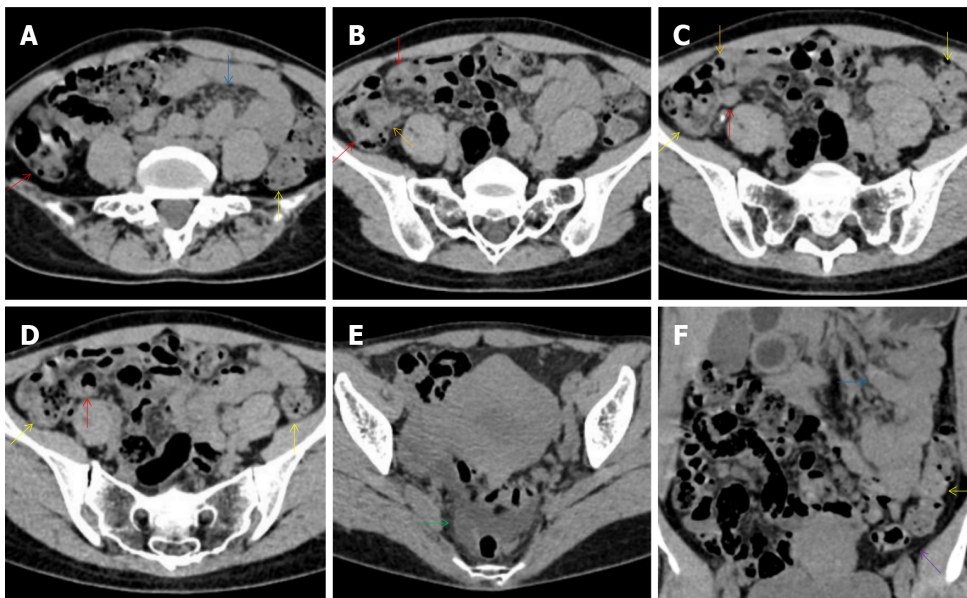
Characteristic images in case 8. A-C: Characteristic images of the ileocecal region and the small intestine. The ileocecal valve (red arrows) was thickened, strictured and stratified. The distal ileum (yellow arrows) were significantly thickened with intramural gas and wrapped by prominent mesenteric fat stranding, which suggested the presence of aggravated inflammatory damage in the distal ileum and ileocecal region; D-H: Characteristic images of the small intestine. In the ileocecal region, the ileum adhered to the cecum, and the cecum was thickened and stratified. In other colonic segments (orange arrows), the bowel wall was also thickened and stratified, and the lumen was dilated in some segments and collapsed in other segments. From the jejunum to the proximal ileum (green arrows), the wall was fibrotic and thickened and the lumen was gas-filled. Several segments of adhesive bowel loop were present in the small bowel. Noticeably, panabdominal silt-like hypervascular fat deposition wrapped the adhesive and widened small bowel loop (creeping fat sign), which suggested the presence of chronic transmural inflammatory damage and a diagnosis of Crohn's disease; I: Characteristic image of the chest computed tomography (CT) scan. Chest CT showed exudative lesions in the left pleura in the context of calcified lesions, indicating the reactivation of an old tuberculosis infection.
